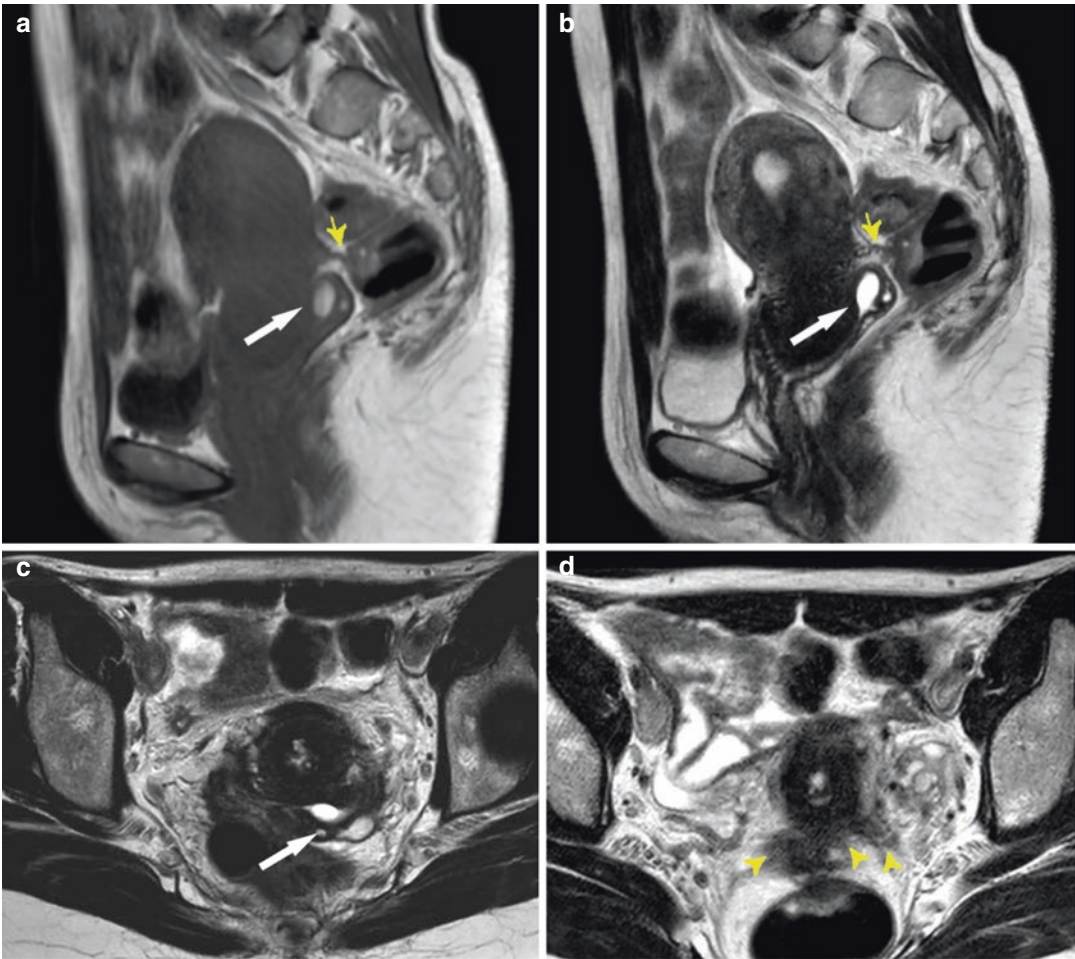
Posterior compartment endometriosis in 45-year-old woman with a history of chronic pelvic pain and dyspareunia. Sagittal T1-weighted (a), sagittal T2-weighted (b) and axial T2-weighted MR images show a large solid nodular implant in the rectovaginal septum and retrocervical area (white arrow) with intermingled high signal foci due to bloody content. Sagittal
